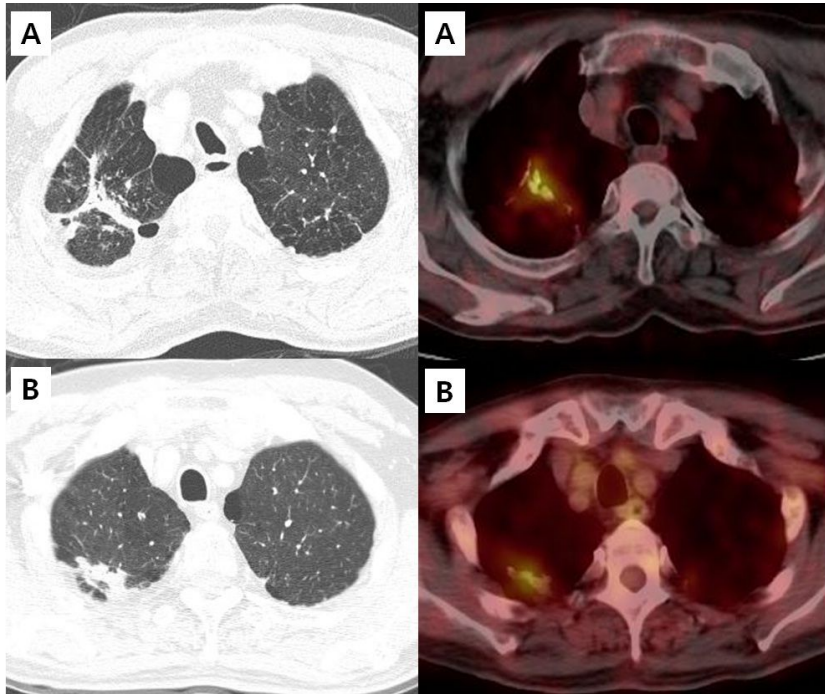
Chest CT and ^{18}F -FDG PET/CT findings of two participants with old healed TB, showing increased FDG uptake.
